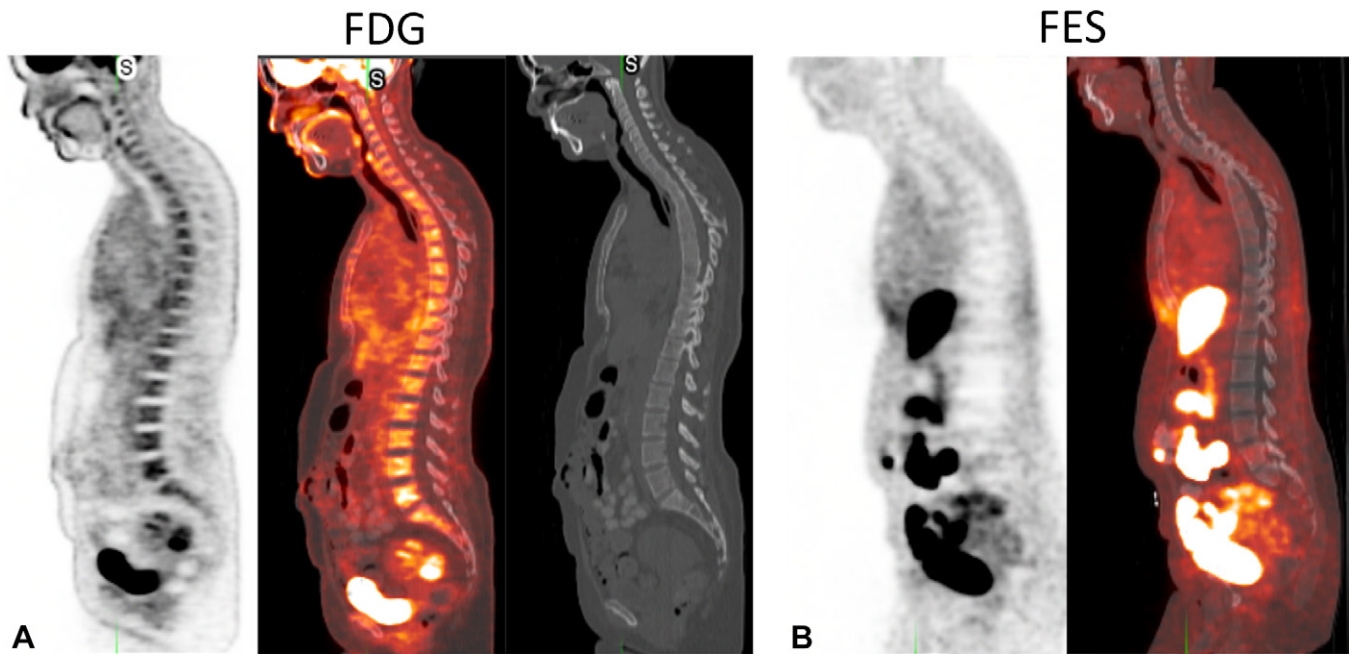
Metastatic ER-positive invasive ductal carcinoma in a 43-year-old woman. (A) Sagittal FDG PET (left) and fused FDG PET/CT (middle) images show uptake throughout the bone marrow, although the corresponding sagittal anatomic CT image (right) did not demonstrate vertebral abnormalities. This distribution of FDG uptake is indeterminate and could reflect widespread marrow disease or reactive marrow (SUV scale, 0–3.5). (B) Sagittal FES PET (left) and fused FES PET/CT (right) images show no FES uptake in the bone marrow, clarifying that the FDG findings represented reactive marrow (SUV scale, 0–5). The patient did not show osseous metastasis in multiple years of imaging follow-up.
